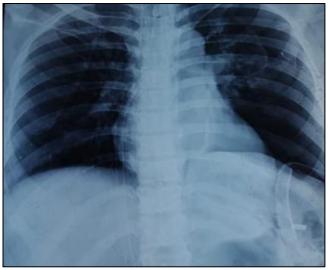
Post-Operative X-Ray with ICD in Situ.
